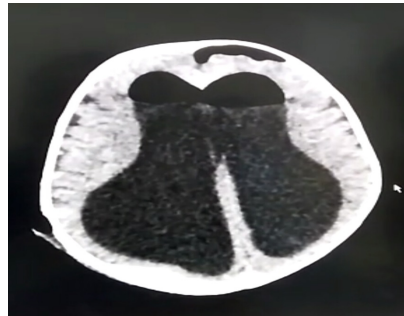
Follow up CT brain scan one month postoperative of ETV.
